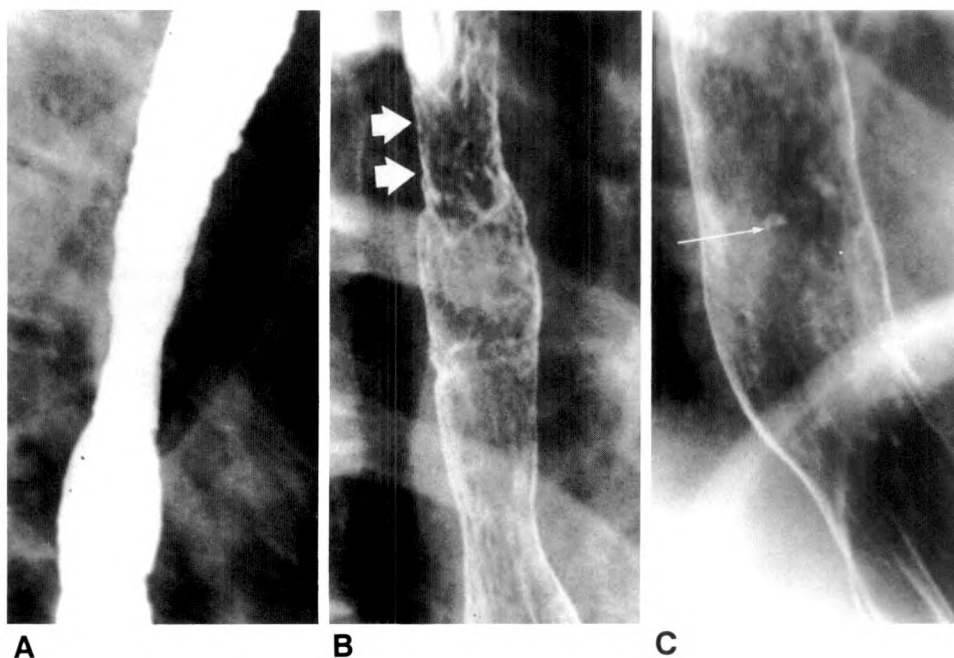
Esophagram in 19-year-old man shows diffuse esophageal ulcers (*thin arrow*), high esophageal stricture (*broad arrows*), and patulous lower esophagus. At esophagoscopy, a circular ulcer was seen at stricture site, not visible on radiographs. Columnar epithelium lined esophagus distal to stricture.
